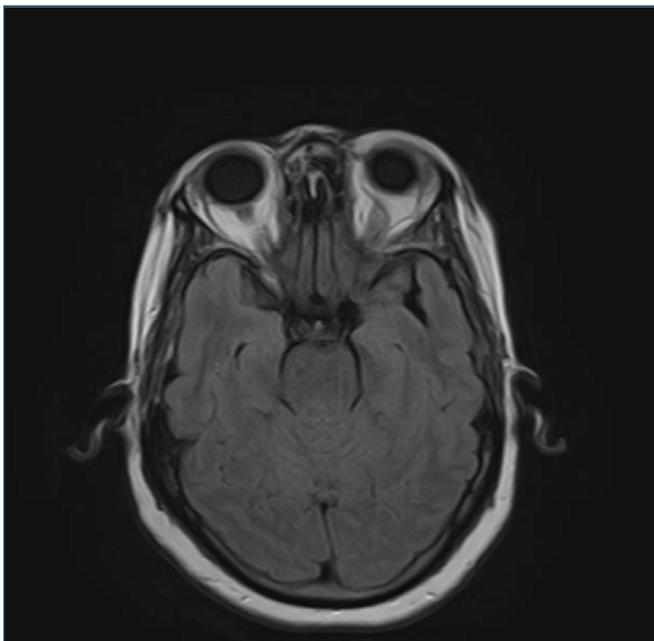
Contrast-enhanced magnetic resonance image of the skull and orbits showing tissue with slight hyposignal on T1-weighted images occupying the left orbital apex.
